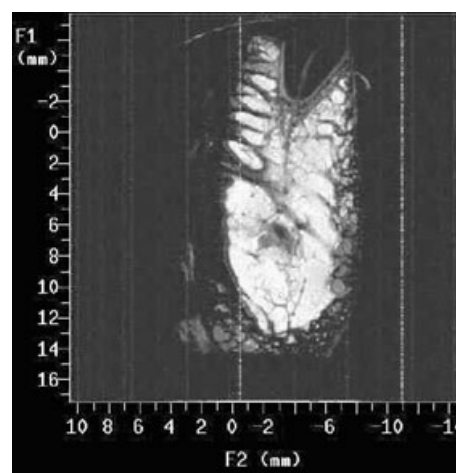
Single cross-sectional slice of a high resolution MRI dataset localized at the incisor region of a dentate anterior human mandible, with the fatty marrow colored white. A black root-form structure corresponds to the root of an incisor tooth. It is surrounded by a small band of intermediate signal intensity, representing the periodontal ligament. The dental neurovascular supply is seen as a line of intermediate signal intensity in the middle of the root. The latter descends to the level of a larger structure of intermediate signal intensity (incisive nerve) with a black oval area on top (vascular structure). (Reprinted from Jacobs *et al.* 2007, Copyright 2006, with permission from Elsevier.)
